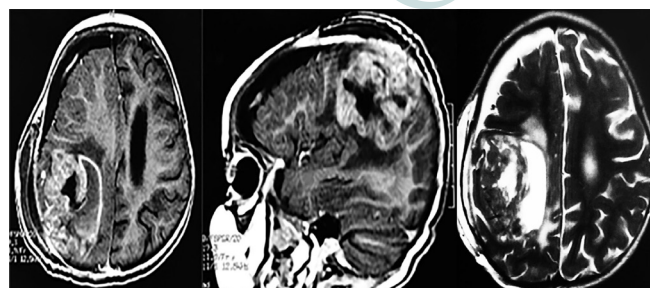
Post puncture magnetic resonance imaging (axial and sagittal T1 post gadolinium and axial T2 weighted images) showing a huge right parietal tumor, enhancing with contrast and with moderate peritumoral edema.
